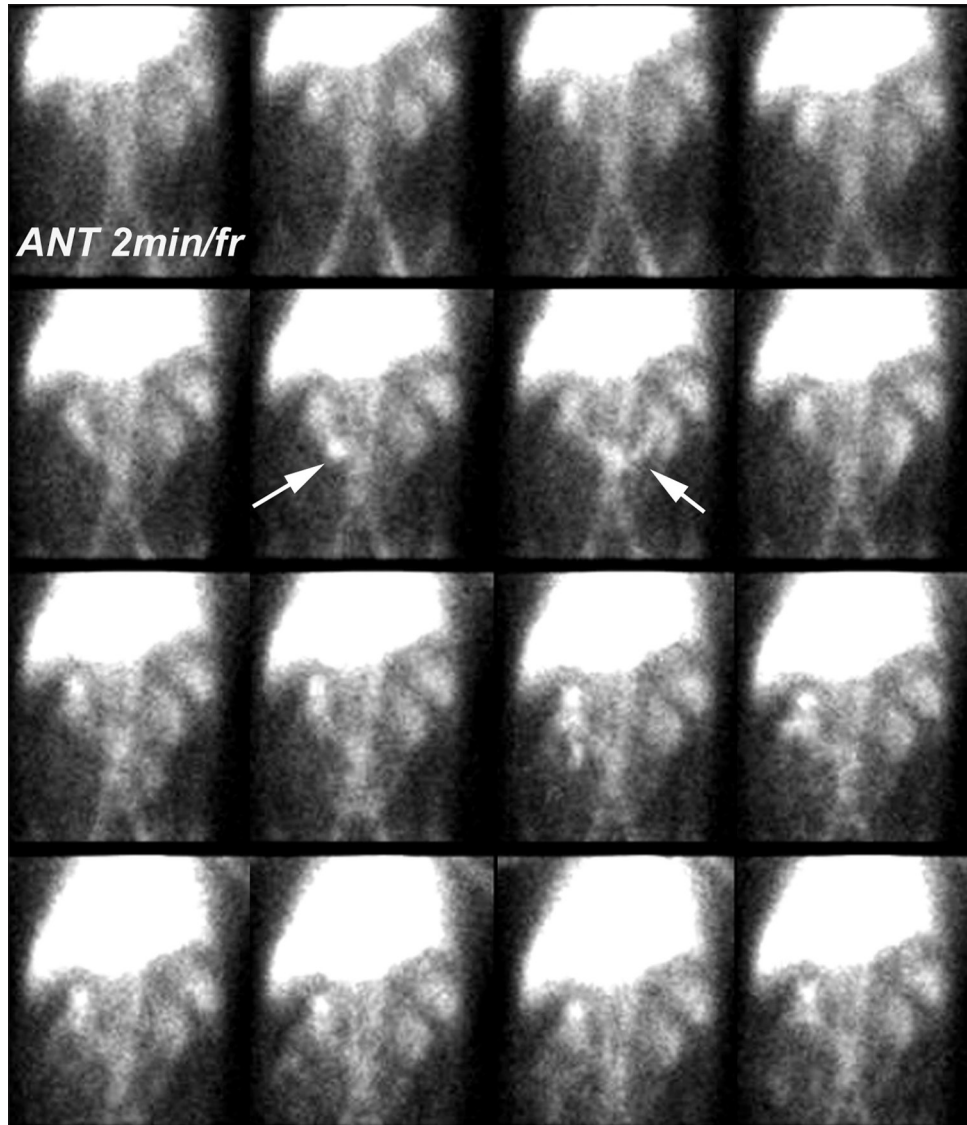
Dynamic scintigraphy using Tc-99m labelled red blood cells showing accumulation and movement of tracer in the mid-abdomen (arrows)
